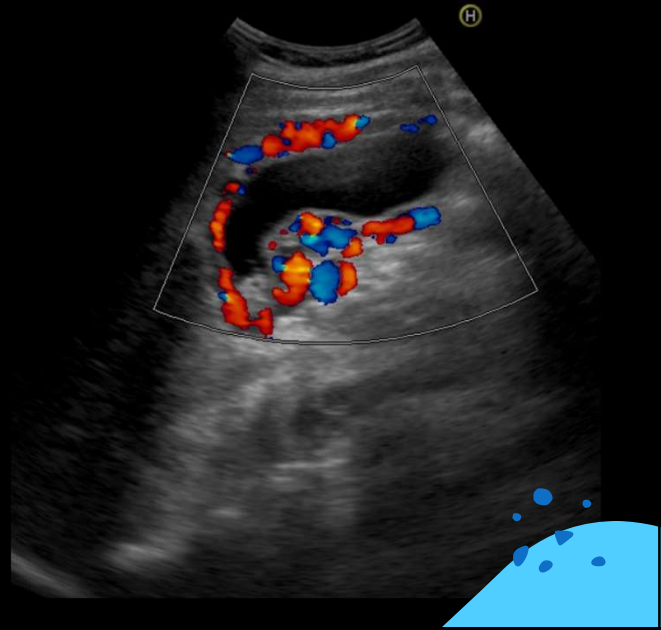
Color Doppler image of gallbladder.
